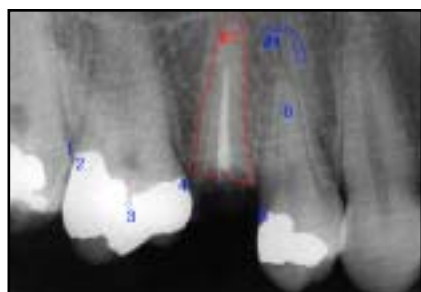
Subtraction radiography: image taken before tooth extraction (I_{BX}). The contour of the tooth (#2, ROI) has been drawn in this image. #1 = ROC.
